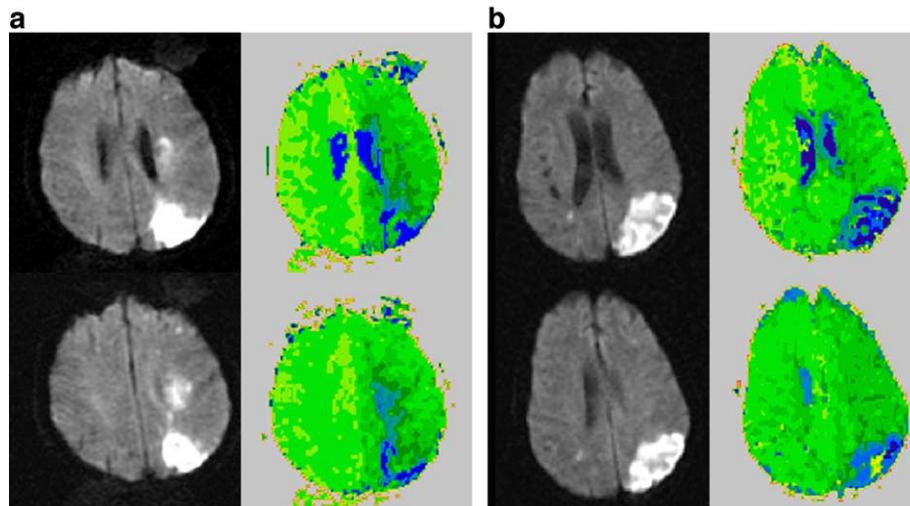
DWI and PWI scans of patients with impaired written word comprehension and lexical decision, and impaired oral reading of words and pseudowords, associated with hypoperfusion of the left angular gyrus.
